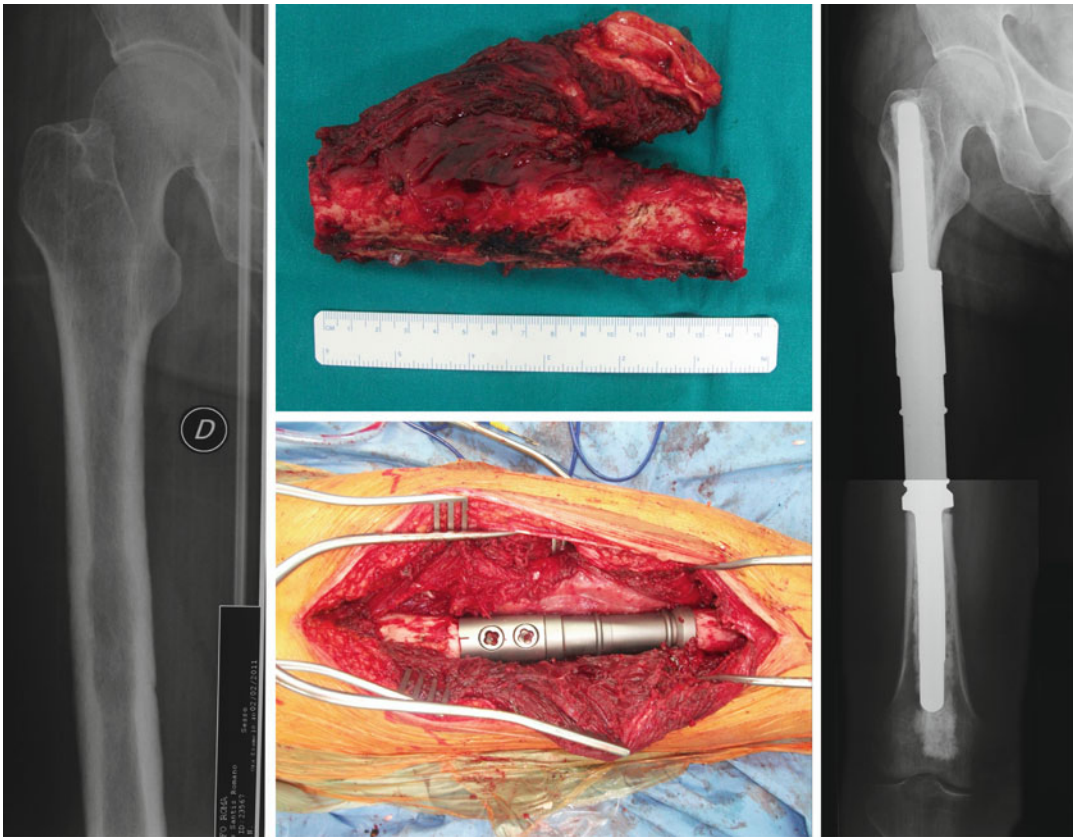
A postoperative X-ray showing a hip prosthesis where the greater and lower trochanters and their muscular insertions were spared
